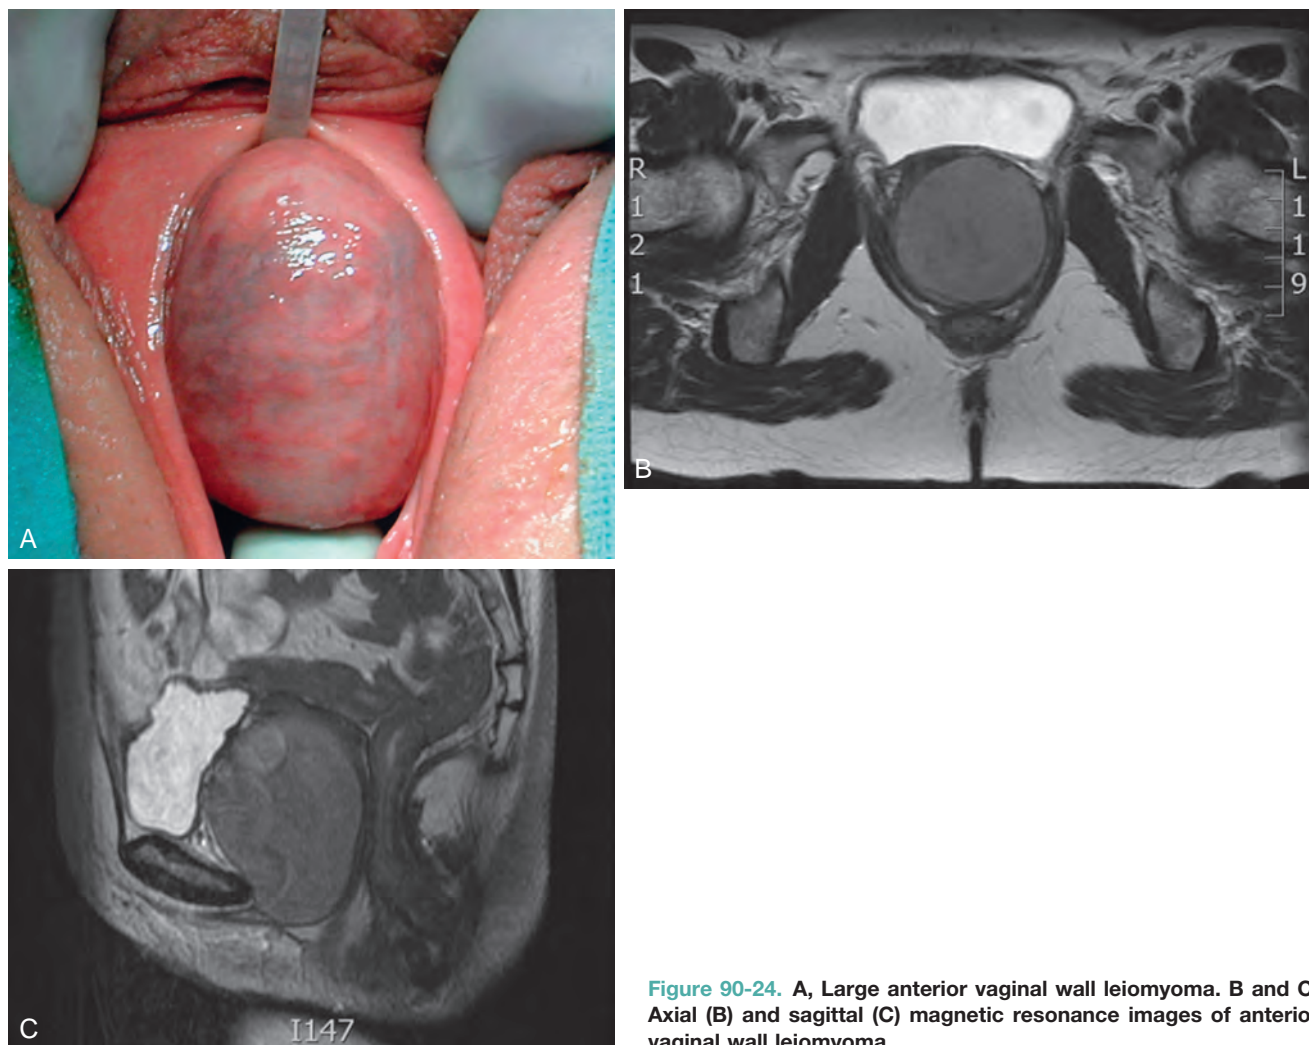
A, Large anterior vaginal wall leiomyoma. B and C, Axial (B) and sagittal (C) magnetic resonance images of anterior vaginal wall leiomyoma.
